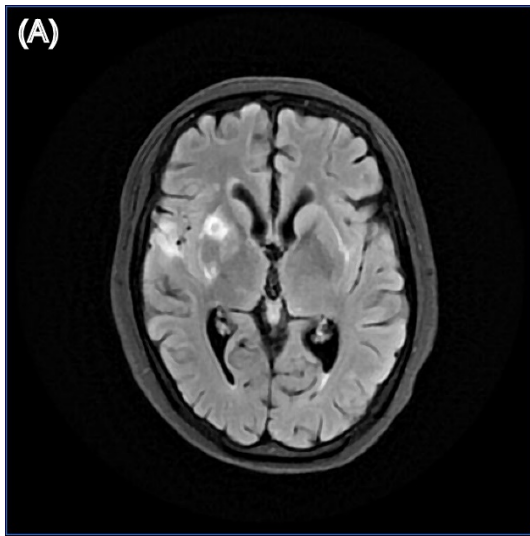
Structural brain MRI images of patient 29. (A) T2-weighted fluid-attenuated inversion recovery (T2-FLAIR) image; (B) Gadolinium-enhanced T1-weighted (Gd-T1w) image.
